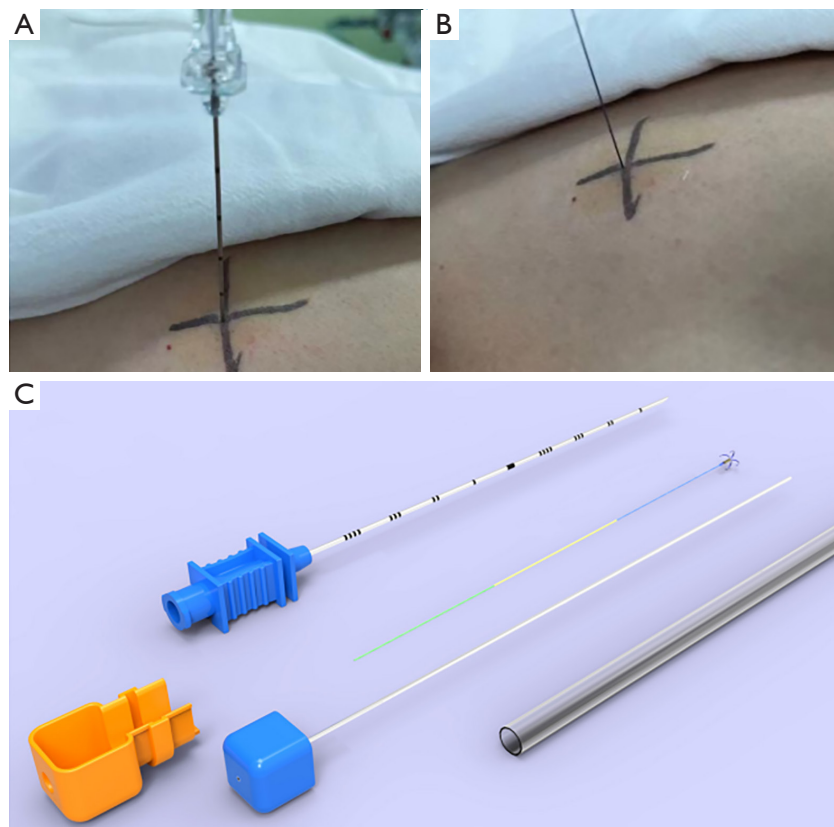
CT-guided needle localization. (A,B) GHIATAS Beaded Breast Localization Wire. (C) Senscure localization needle. CT, computed tomography.
